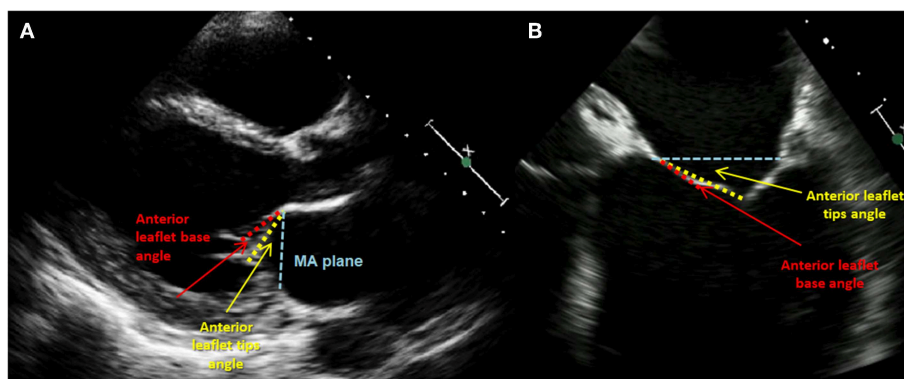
Phenotypes of tethering. (A) Transthoracic echocardiography (TTE), parasternal LAX view: anterior leaflet (AL) tethering with AL bend; (B) transesophageal echocardiography (TEE), midesophageal 4-CH view focused on MV: less pronounced bend and tip angle of the AL.
